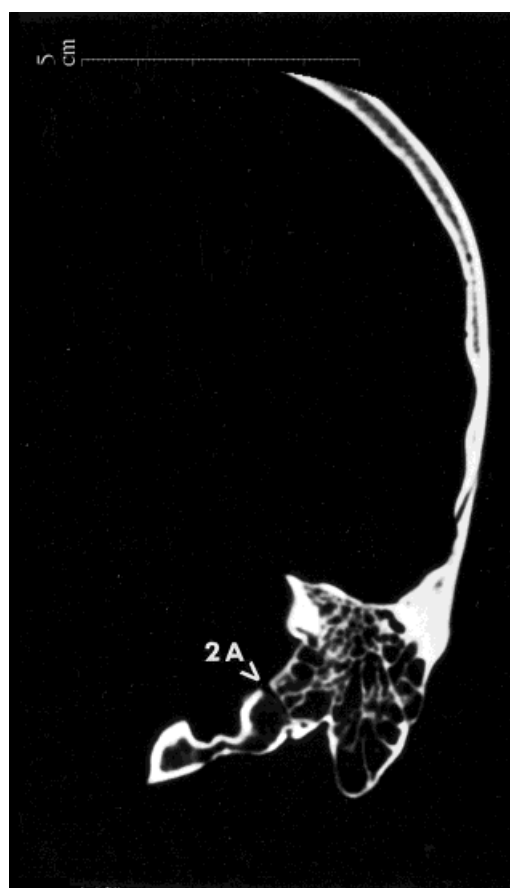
CT sections through the petroexoccipital articulation (HTH 1118) joint fused (see arrowhead).
